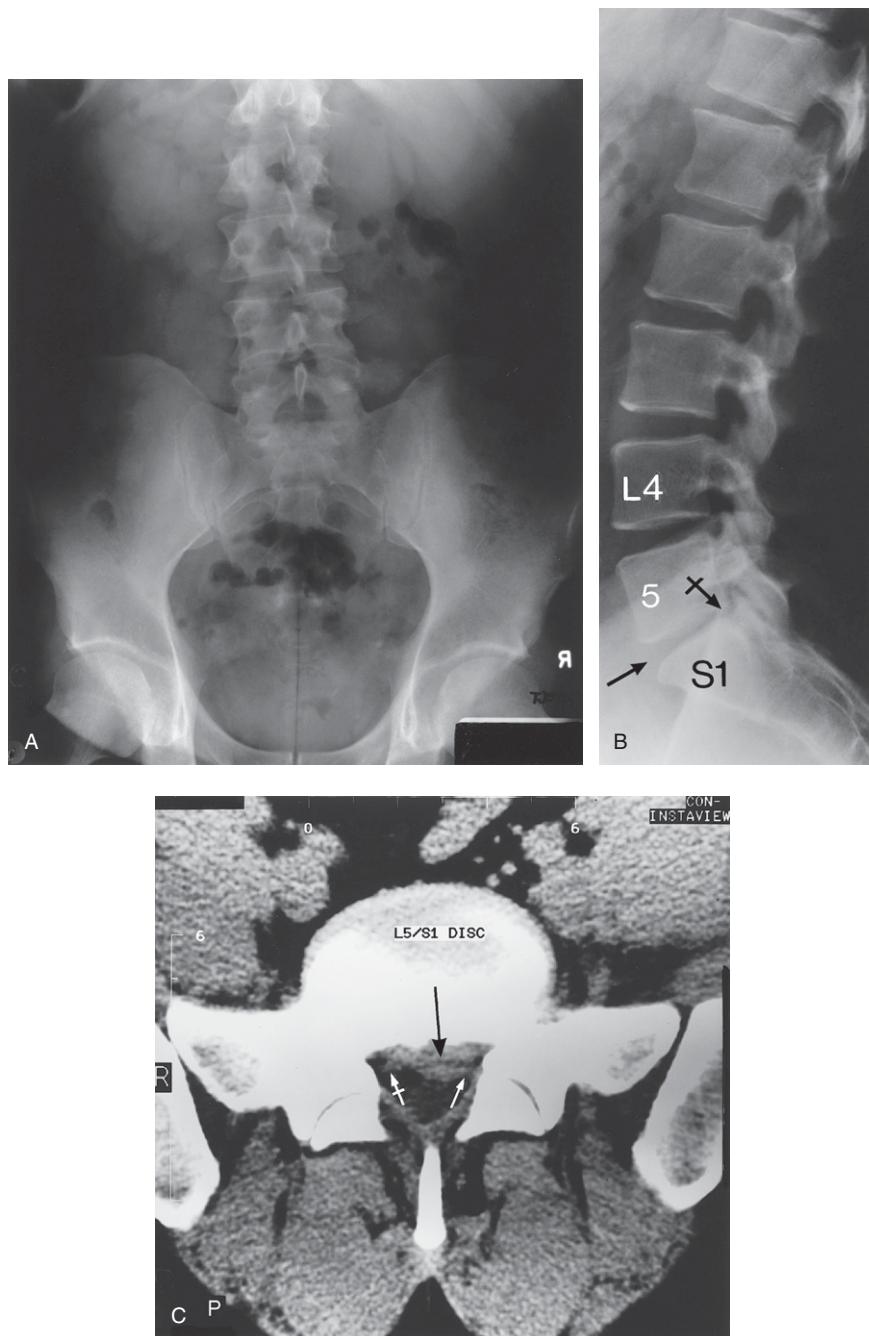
(A) Pelvis and lumbar spine anteroposterior plain X-ray image in the erect posture that shows some degree of antalgic scoliosis (lumbar curvature convex to the left). (B) Lumbar spine lateral plain X-ray image showing the fourth (L4) lumbar vertebra and the disc thinning at L5–S1 (black arrow), with retrolisthesis of L5 on S1 (tailed arrow). (C) Lumbar spine CT axial image at the L5–S1 level showing the large left paracentral disc protrusion (black arrow) compressing the left S1 nerve root (small white arrow). The small white-tailed arrow shows the right S1 nerve root which appears not to be compromised.
